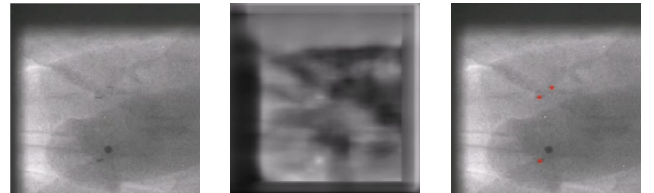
Marker detection for a prostate tumor using template matching. Left: Fiducial markers visible in black through the X-ray image. Middle: NCC template matching output during marker detection. Right: Detected markers marked with red circles.
